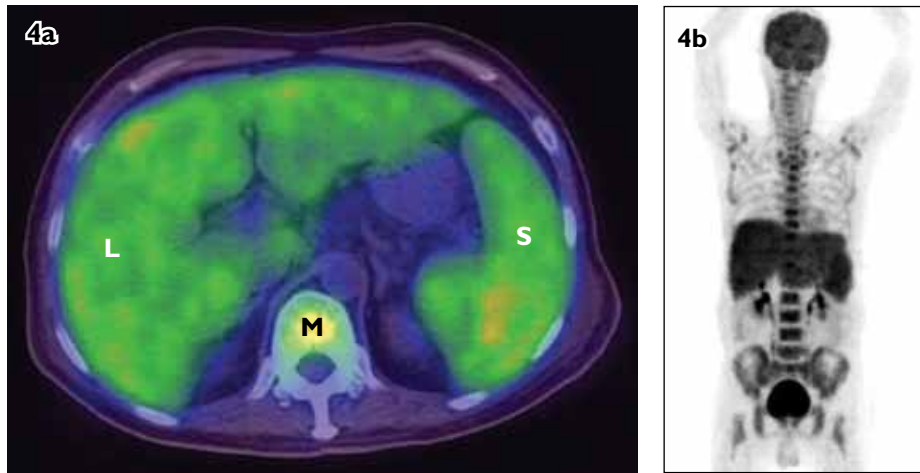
(a) PET/CT and (b) MIP images show a diffuse increase in FDG activity in the liver [L], spleen [S] and marrow [M] in Case 3.
